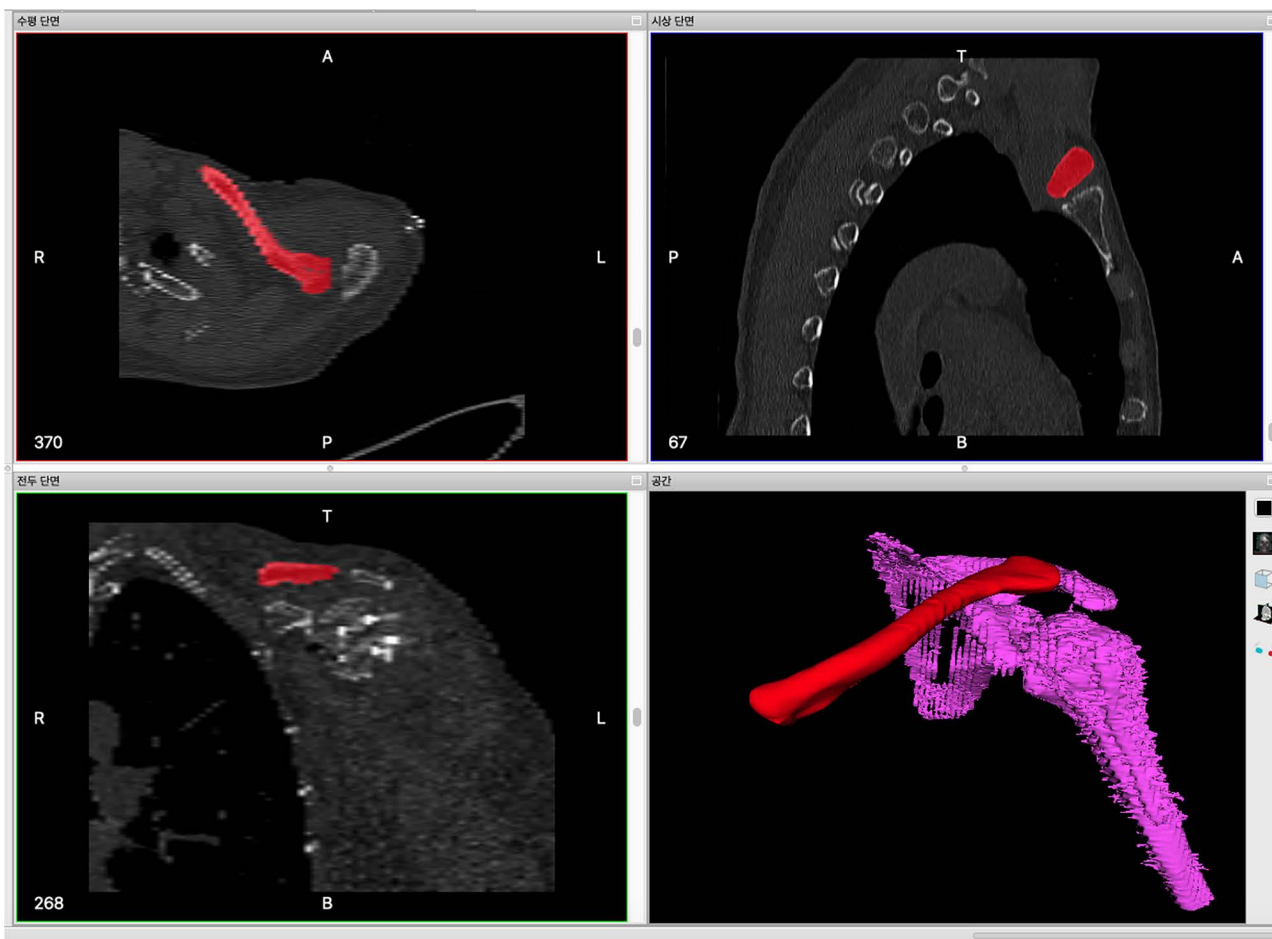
Conversion of axial images of clavicle CT into 3D images through the InVesalius® program. CT = computerized tomography, 3D = 3 dimension.
